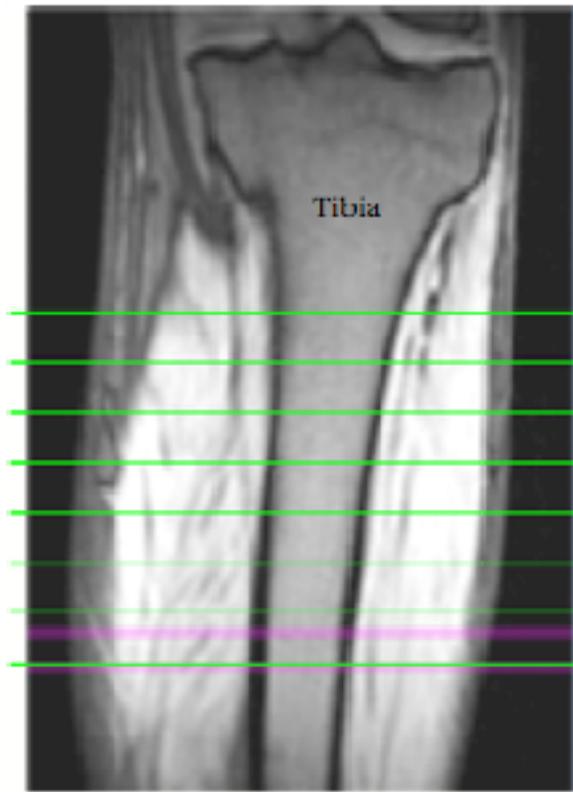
Representative ^1H -MRI coronal image of the calf muscles from a healthy control at 1.5T. Trans-axial images were obtained along the length of the coronal image (represented by horizontal green lines)
